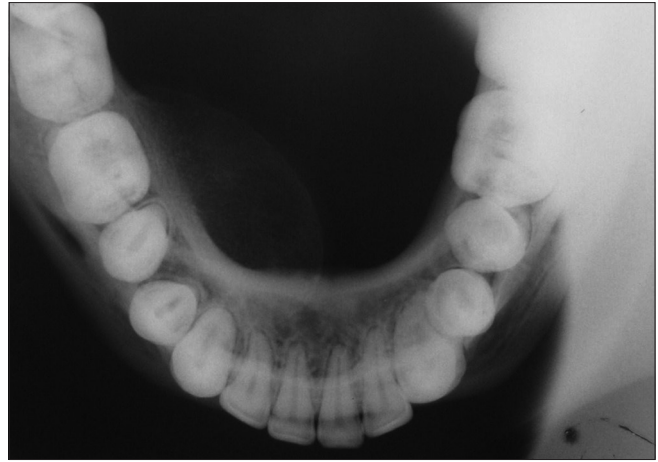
Cross-sectional mandibular occlusal radiograph shows cortical expansion with hazy radiopacity on the lingual surface of mandible extending from 41 to 47 region
